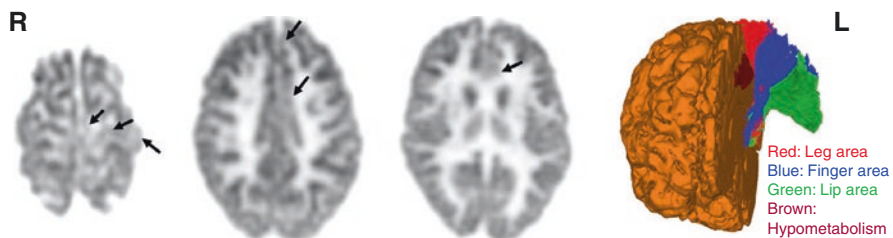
FDG PET in a 14-year-old girl with uncontrolled seizures for 8 years, beginning with right leg shaking, nonlateralized EEG, and normal MRI, showing hypometabolism in the left motor cortex, extending into left anteromedial frontal cortex (*arrows*). The diffusion tensor analysis showing superimposition of hypometabolic region upon corticospinal tract
